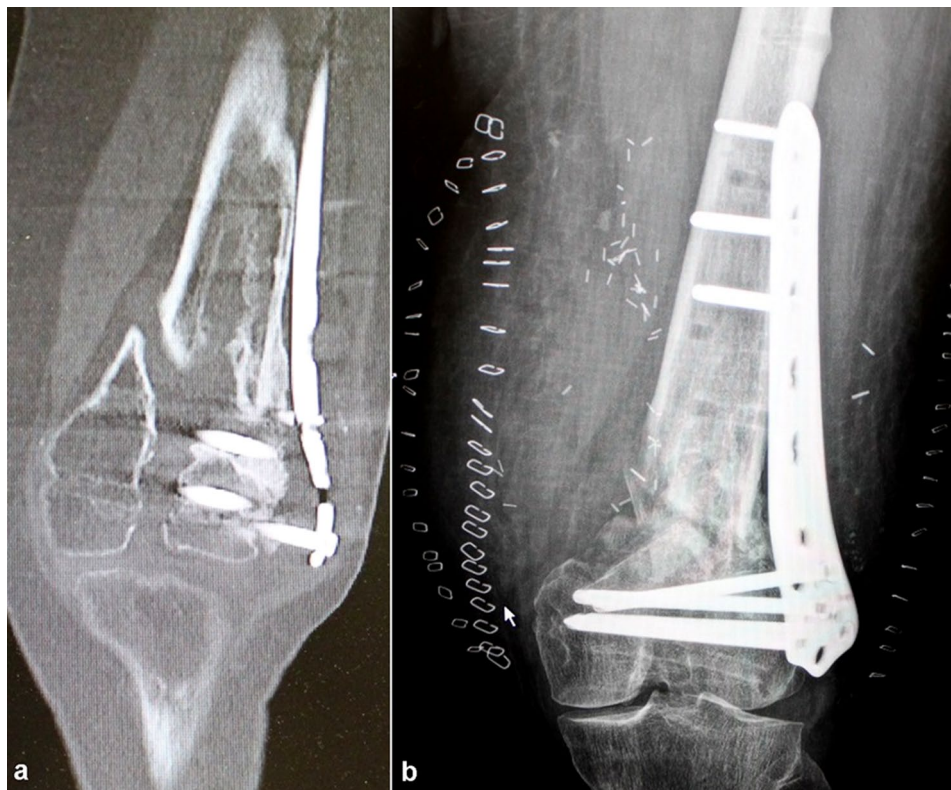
A 55-years-old female patient with a supracondylar distal femoral fracture. X-rays before (a) and after (b). (a) non-union; (b) result at 12 month after reconstruction
